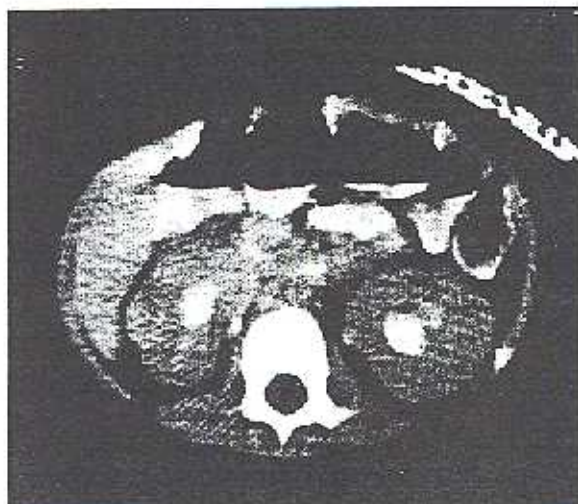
CT-scan following the first cycle of chemotherapy with dramatic reduction in renal size.
